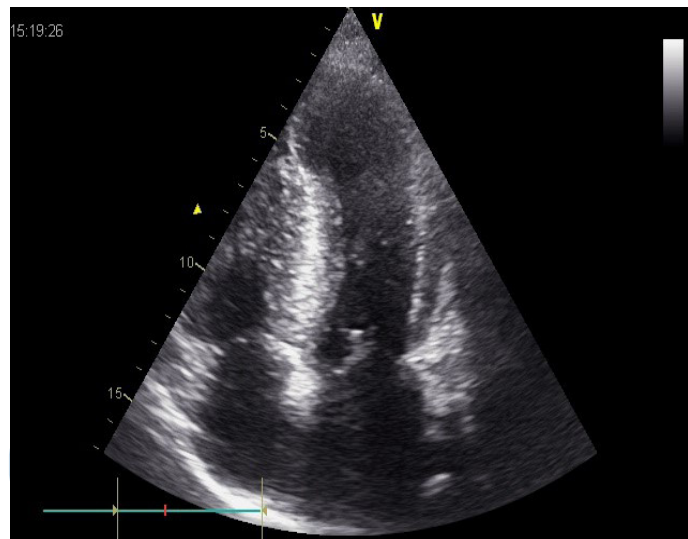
Apical four-chamber view, during diastole presented hypertrophy of the left ventricle walls, especially interventricular septum.
